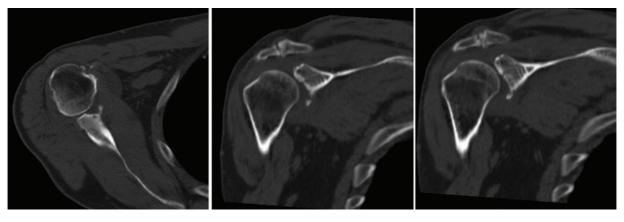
Computed tomography images - Bony Bankart lesion of about 50% of the anteroinferior part of the glenoid with bone fragmentation.
